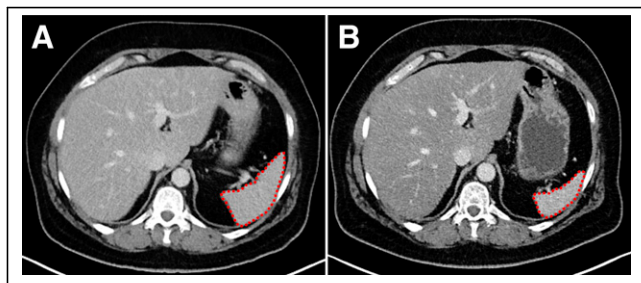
CT images from patient with ileal neuroendocrine tumor presenting with hepatic and bone metastases. Patient underwent total of 8 cycles of ^{177}Lu -DOTATATE treatment. (A) Baseline splenic volume was measured at 161 cm^3 . (B) At 1-y follow-up after initiation of treatment, splenic volume was reduced to 79 cm^3 , representing volume reduction of 51%.
